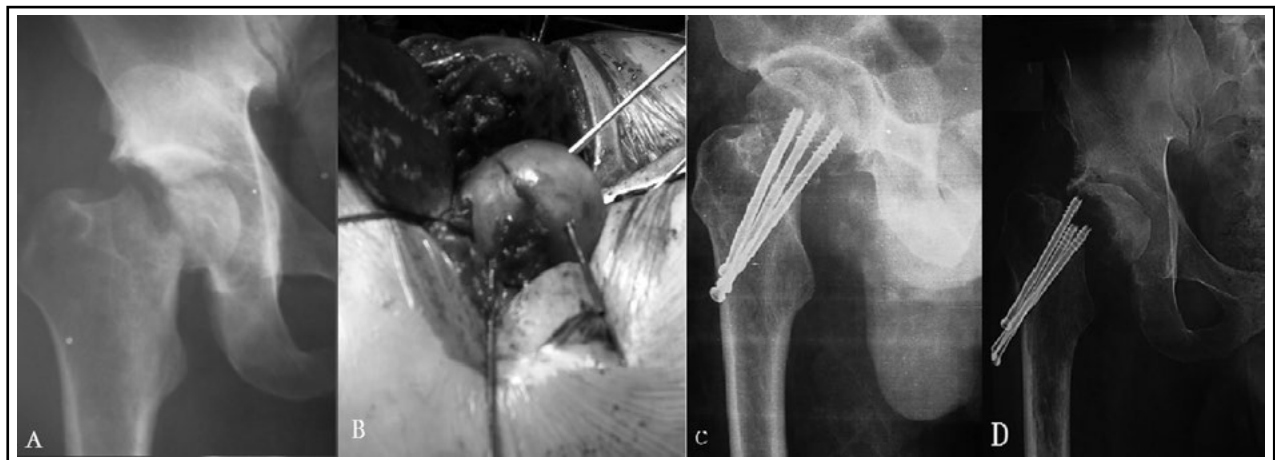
A male patient, with Type-III Pipkin fracture (A), In the initial surgery, the femoral head ligament was cut to reduce the femoral head fracture with cannulated screws. (B, C), In the 36<sup>th</sup> month follow-up, he suffered from pain and joint movement disorder with obvious collapse and necrosis of the femoral head showed on X-ray. The Harris Hip Score was rated as poor (D).
